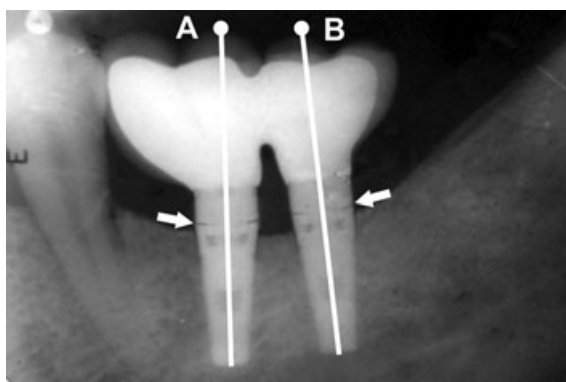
Intraoral periapical (IOPA) radiograph of an implant-retained left mandibular first and second molar prosthesis: Note the white vertical lines indicating the long axes of the implant bodies, and points A and B indicating the site of entry for the access-opening preparation. Arrows indicate the gaps developed at the implant body and abutment junction due to abutment-screw loosening.
